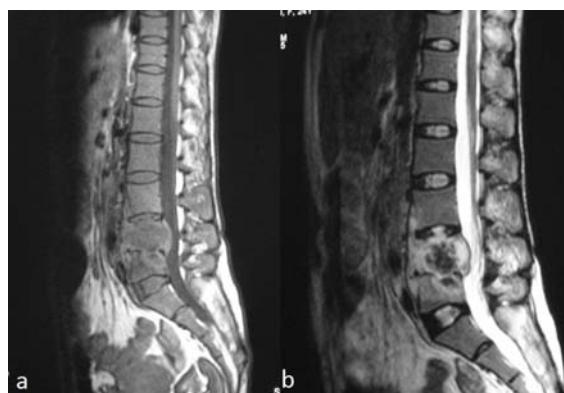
T1W (a) and T2W (b) sagittal MR images of lumbar spine demonstrates altered signal intensity of L4 and L5 vertebral bodies with loss of intervening intervertebral disc space. Evidence of intraosseous abscess, sub ligamentous spread and posterior extension into extradural spinal canal with narrowing of the thecal sac is also seen.
